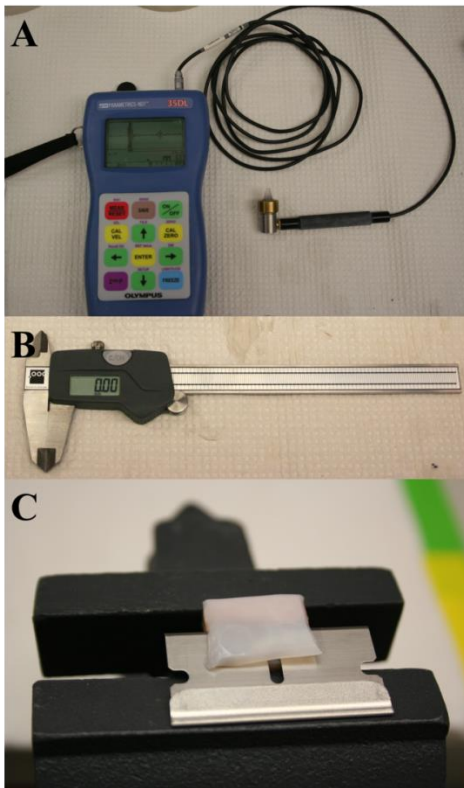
The cartilage measurement devices used to calculate strain measurements from stress application experiments are shown here (A and B). The extraction method for validation of the ultrasound device is also shown (C).
